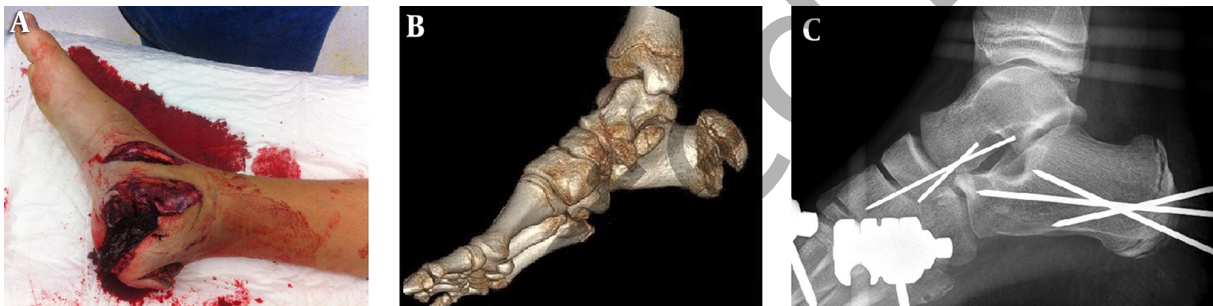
Case 2. A, Trauma photo: Extensive injuries to medial side of the ankle; B, 3D computed tomography reconstruction: fractures of the calcaneus, talar and navicular bone; C preoperative fluoroscopy: internal fixation with 3 K-wires.
